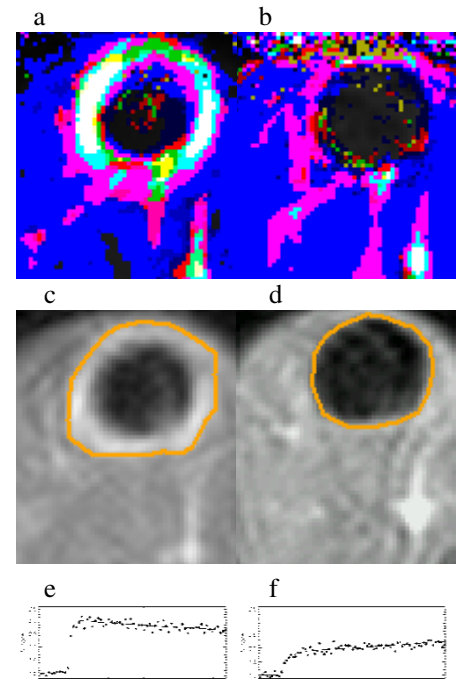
Color-coded DCE-MRI parameter maps of signal-amplitude and k_{ep} pre- (a) and post-therapy (b) of a liver metastasis of a MTC patient. Pre- (c) and post-treatment (d) images show the metastasis with the region of interest (ROI). Signal intensity curves within the tumor ROI from pre- (e) and post-therapy (f) are plotted.
